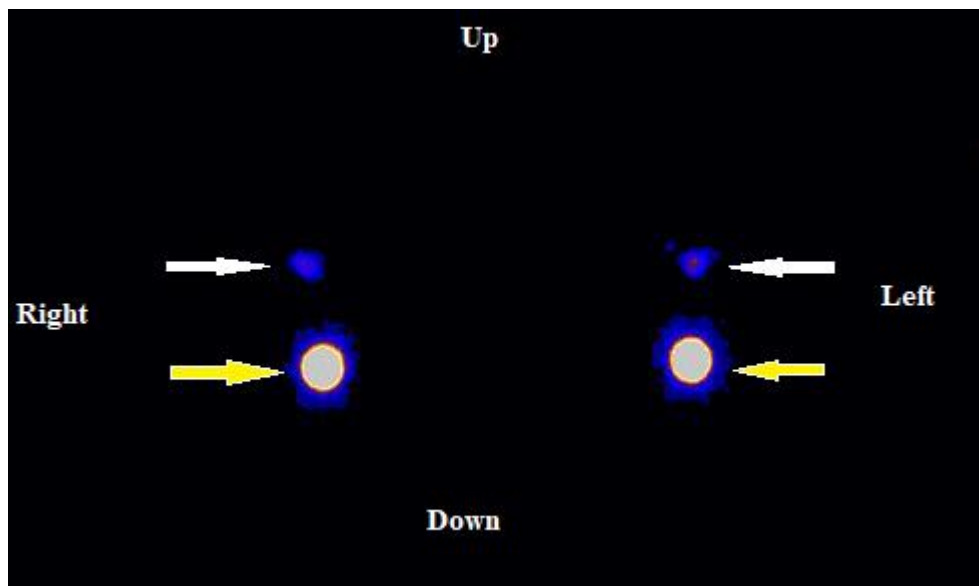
Planar lymphoscintigraphy in anterior-posterior orientation of a patient following peri-areolar injection of ^{99m}Tc -labelled colloids in both breasts. White arrows indicate radiocolloid uptake in Sentinel Lymph Nodes roughly located in the axillae. Yellow arrows indicate injection sites.
